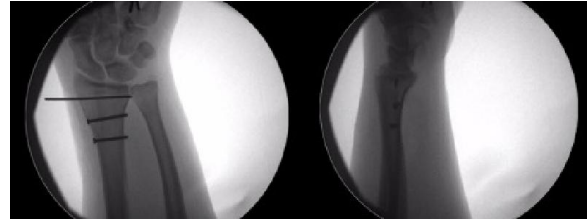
AP and oblique radiographs at 2 year follow up. No arthritic changes seen in wrist joint
